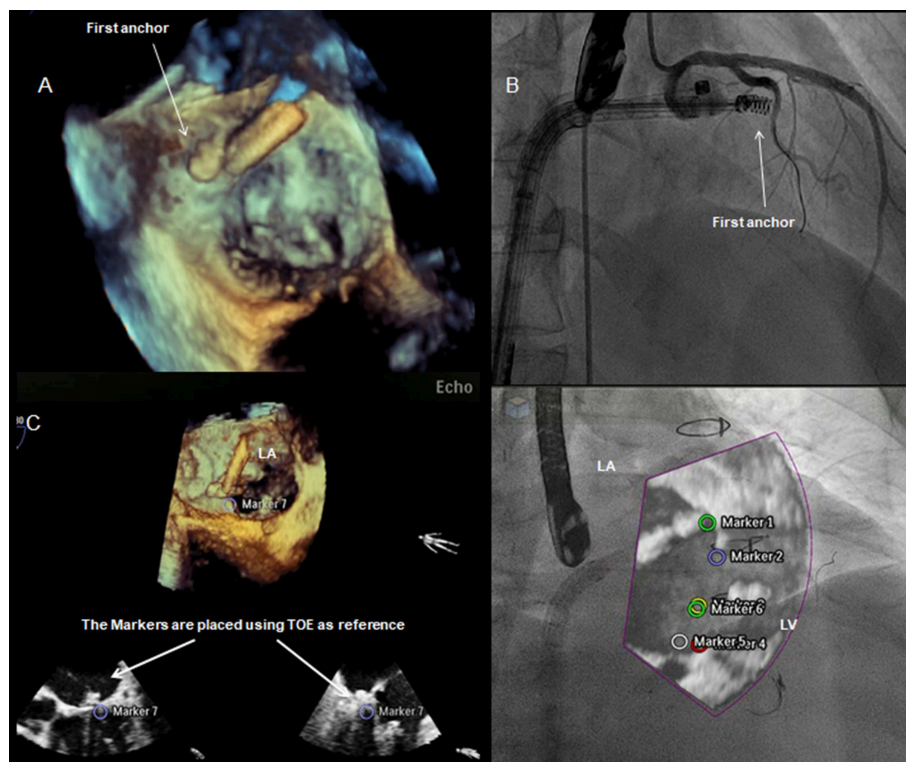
Integrated intra-procedural guidance for Cardioband: (A,C) real-time 3D transesophageal echocardiography facilitates the navigation and delivery of the first anchor; (B) fluoroscopy: the use of coronary wire may serve as a radiographic marker and a potential railway for bailout strategies. Fusion imaging allows to display an overlap image of the “echo-structures” in the fluoro-images. This could be a valuable tool in the presence of difficult anatomies and in the first phase of the operator’s learning curve.
